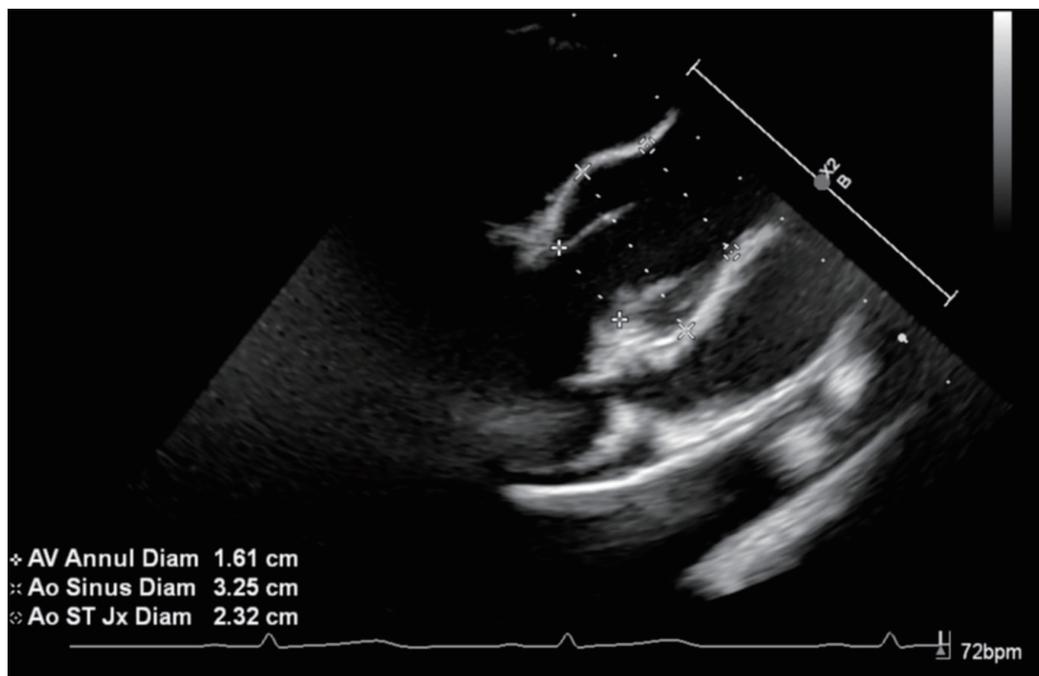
Preoperative echocardiograph image showing severe dilatation of the aortic root.
